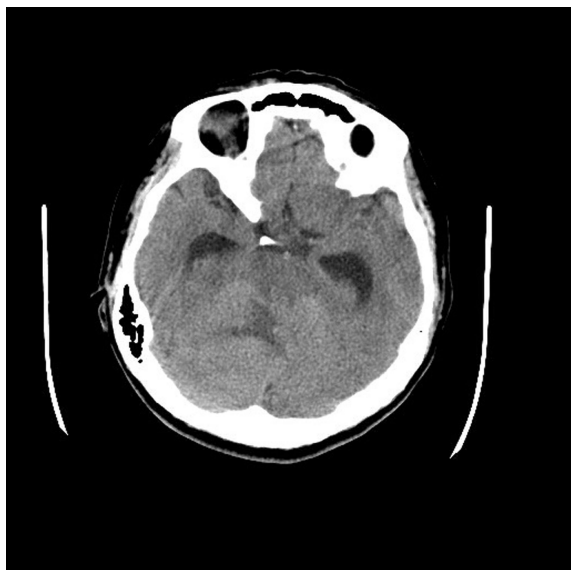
Axial CT scan of the head with contrast showing disruption in the cerebellum. This image is highly indicative of tissue disruption in the cerebellum.
